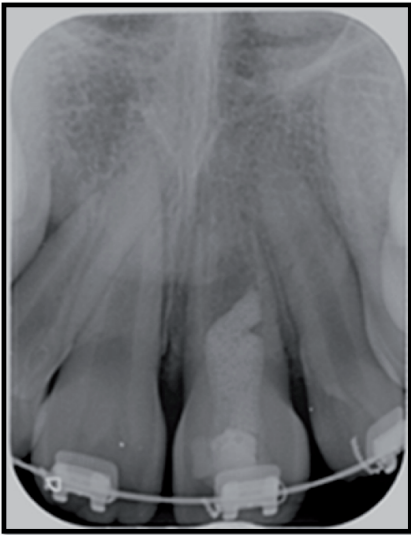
2 years later: Healing of the periapical periodontitis.
